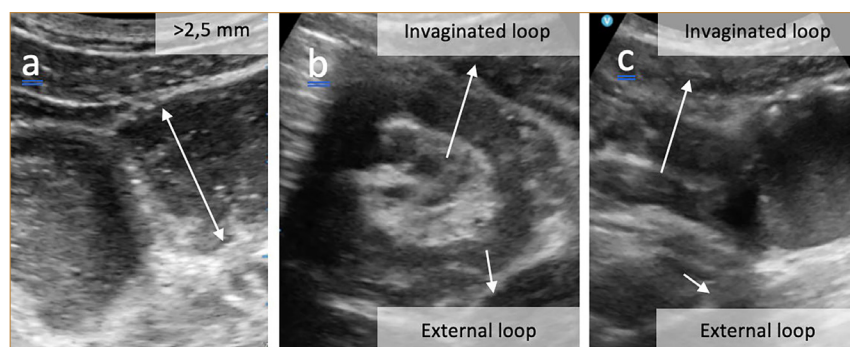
Point-of-care ultrasound showing (a) dilated small bowel, (b) target sign image in which the transverse view of the intussusception shows the receiving digestive loop externally and the invaginated digestive loop in the center, and (c) longitudinal view of the intussusception.
